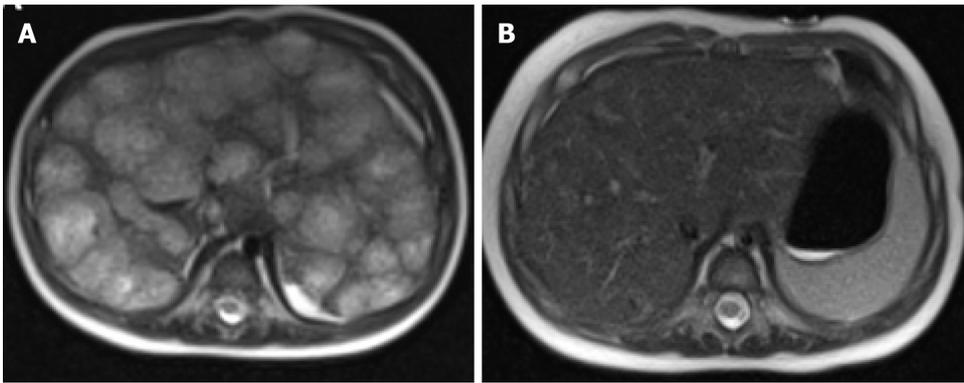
Magnetic resonance imaging results. A: Magnetic resonance imaging (MRI) of liver in a 4-month-old at the time of the diagnosis, axial T2-weighted (HASTE) image showing multiple nodular hyperintense lesions with centripetal fill-in on the delayed phase; B: MRI of the liver 3 mo after starting atenolol treatment, subsequent axial T2-weighted image showing interval decrease in size of enhancing lesions and improving hepatomegaly.
